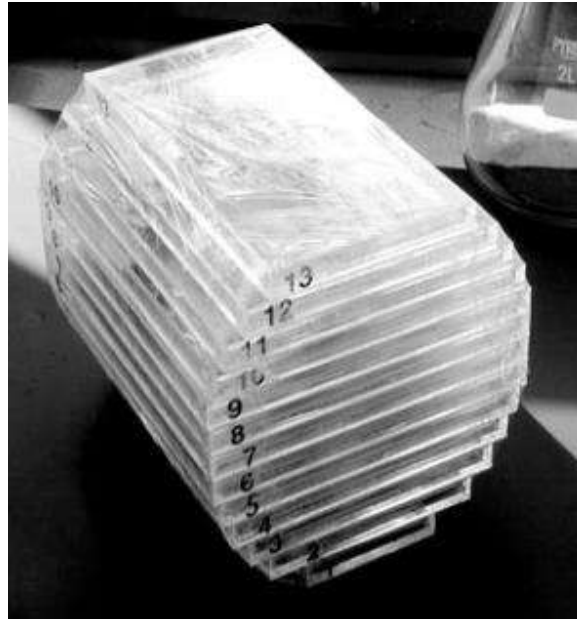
Post-mortem MRI. Fixed post-mortem coronal brain slices were sealed in polythene bags and placed in ‘self-locking’ stack to fit into the MRI scanner (Fernando et al., 2004)
